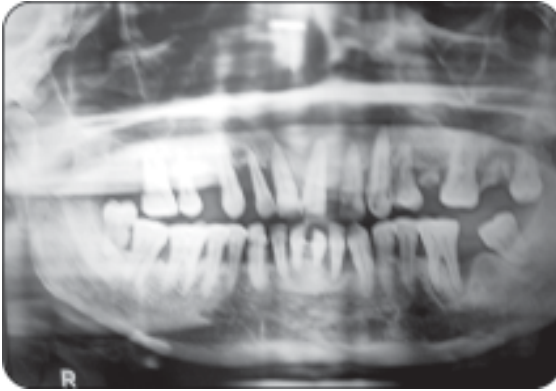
X-ray neurogenic sarcoma
